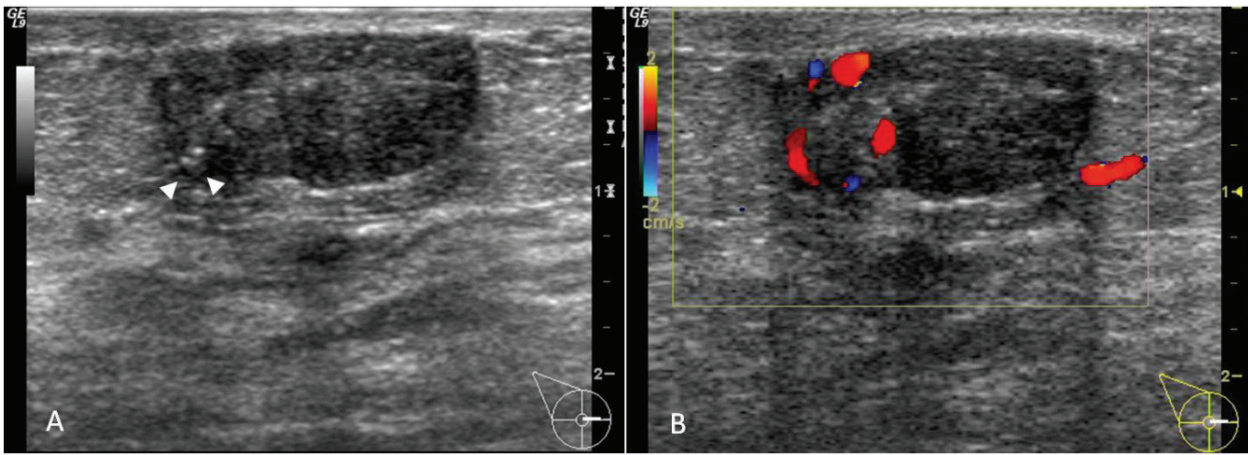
Gray-scale ultrasonography (panel A) showed an 18-mm, oval-shape hypoechoic mass with microlobulated margins at the medial aspect and echogenic foci consistent with calcifications (arrowheads). Color doppler study (panel B) showed focal internal vascularity at the medial aspect correlated with the area of microlobulated margins on the gray-scale image.
